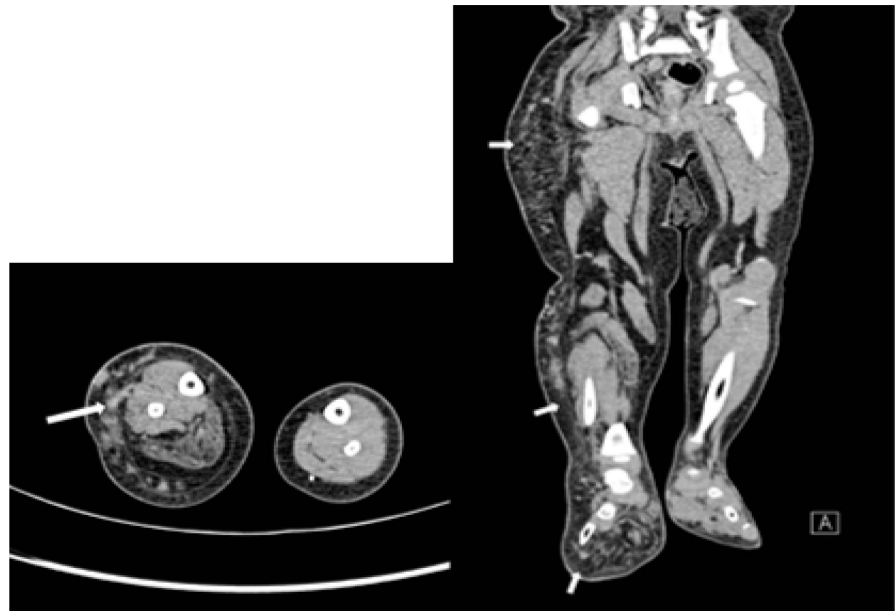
Contrast-enhanced Axial and coronal reformatted CT of the lower limbs shows overgrowth of the right lower limb with fatty infiltration of the subcutaneous tissues (short arrows). The right lower limb is consequently considerably larger than the left. Tortuous venous collateral seen within the subcutaneous tissues (long arrow).
